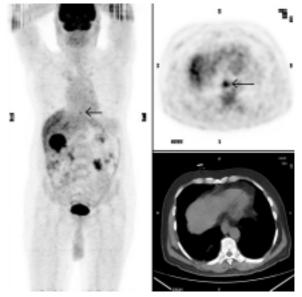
18F-FDG PET/CT Showing Focal Increase of 18F-FDG Uptake in the Gastroesophageal Junction. See arrows on maximum intensity projection image on the left and transaxial PET image on the upper right. Liver and mesenteric metastatic lesions have intense 18F-FDG uptake
